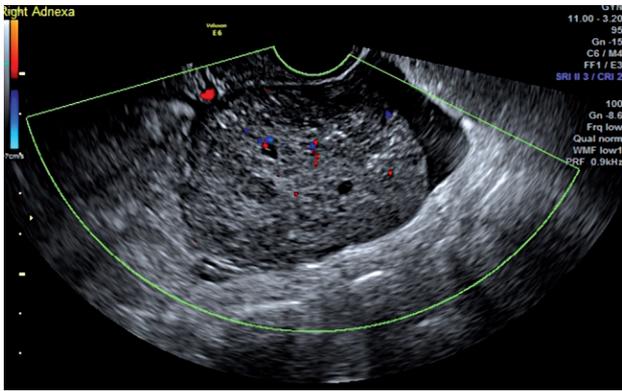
a) Right adnexal heterogeneous mass with colour Doppler flow present in TVUS.
